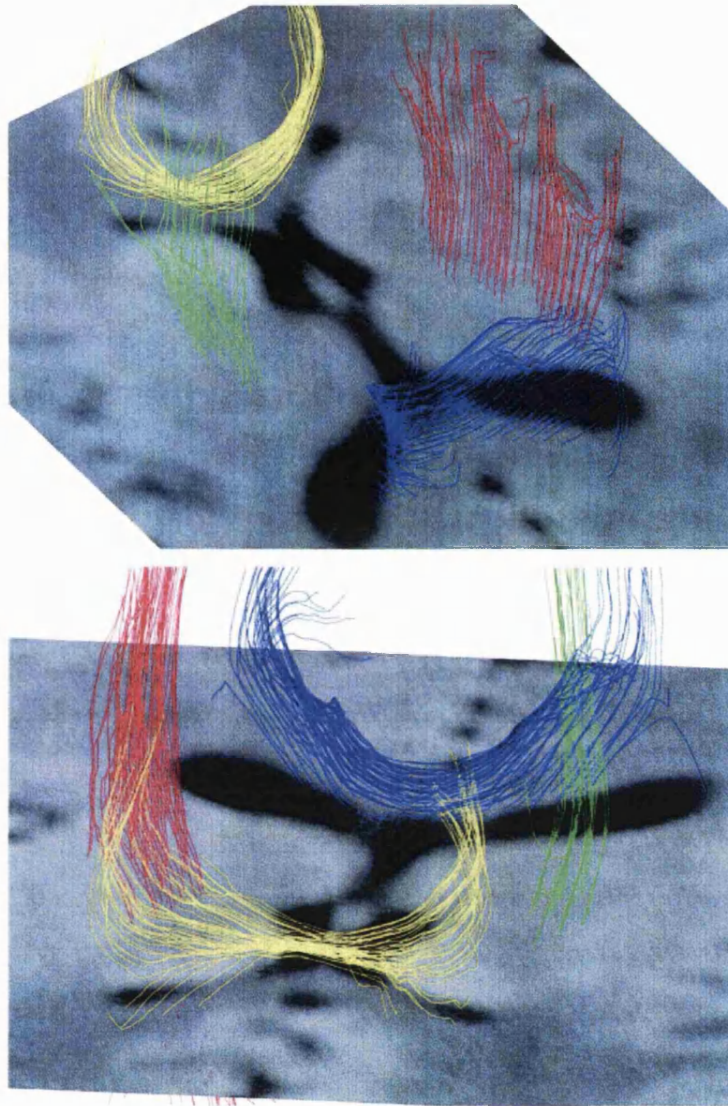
Three-dimensional tractography of a normal subject showing the anterior (yellow) and posterior (blue) part of the corpus callosum, and the left and right (green and red) cortico-spinal tract, superimposed on an axial MR image through the lateral ventricles. Top and bottom images present two different views of the same tractography result (reproduced from Westin, C.-F. et al. 2002 (Westin *et al.* 2002))
